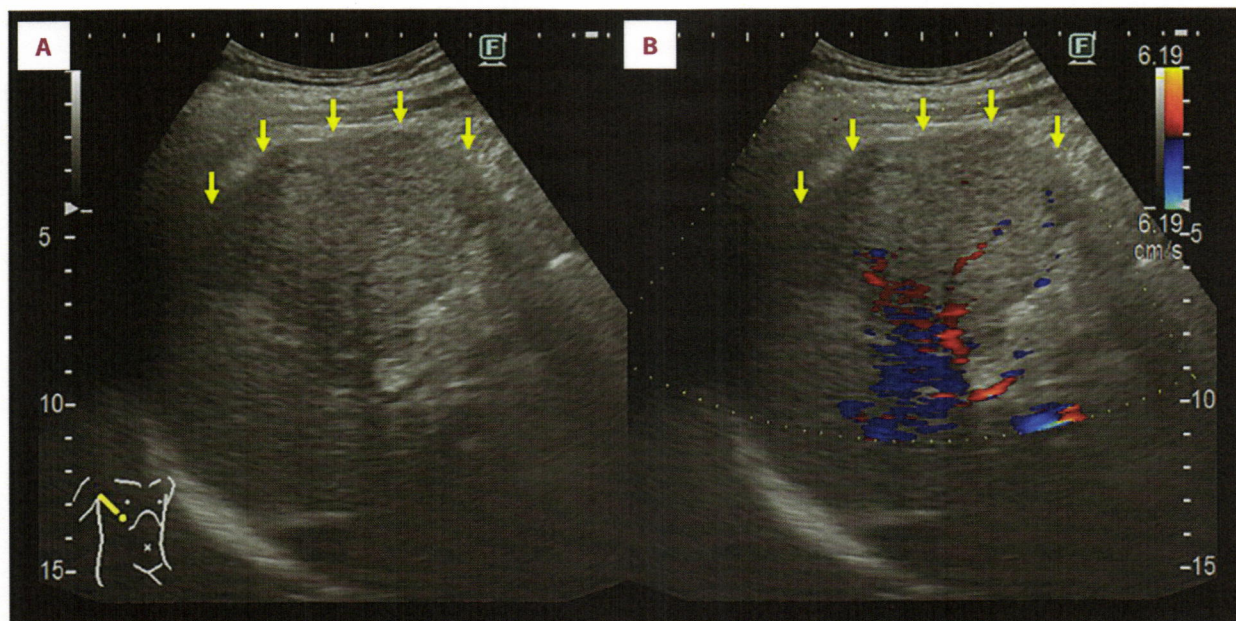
US findings 18 days after the initial diagnosis. The hepatic tumor (yellow arrows) had enlarged to 75×67 mm and appeared as an irregularly-shaped hypoechoic mass on plain US (A). Doppler US detected only a few feeding arteries within the tumor (B). US – ultrasound.
